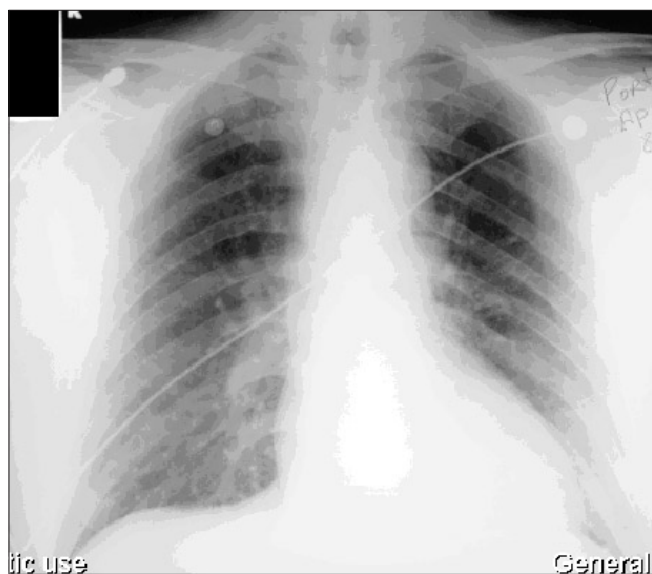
Results of chest x-ray of 59-year-old man with chest pain.
